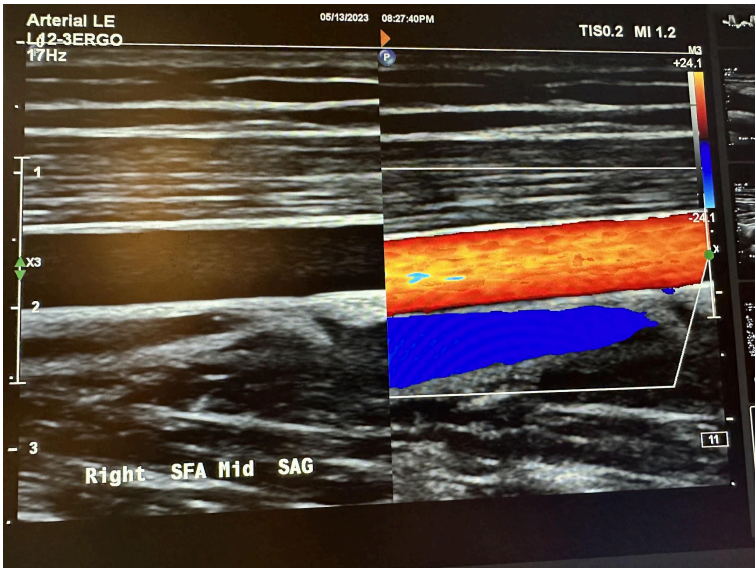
Sagittal image of the right middle superficial femoral artery without color Doppler and with color Doppler.
